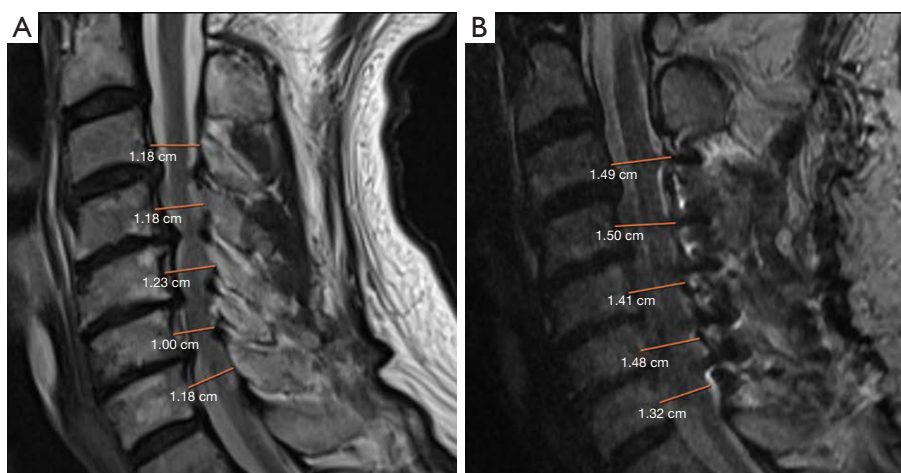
Original image of preoperative MRI (A) demonstrating congenital cervical stenosis and in-between critical degenerative spinal stenosis that extended from C3–C7. An MRI performed immediately postoperative (B) shows a significantly wider canal. MRI, magnetic resonance imaging.
